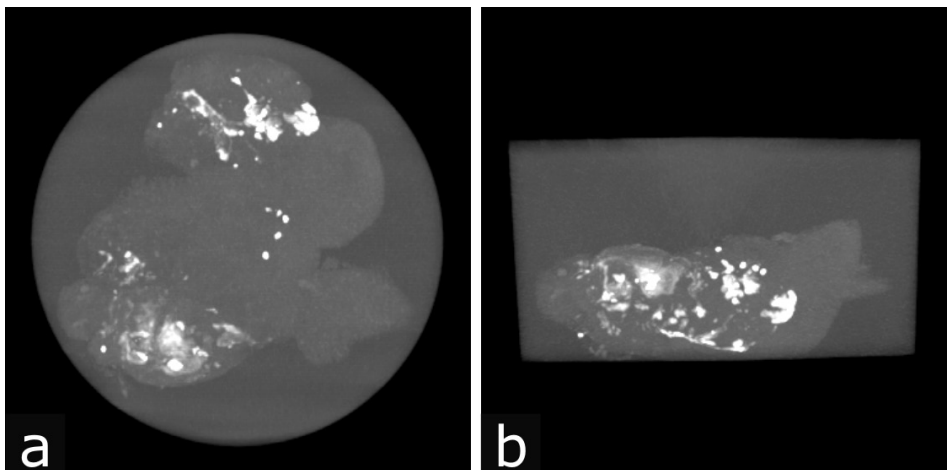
CT images (maximum-intensity projections) of the *ex-vivo* liver; top view (a) and side view (b). The radiopaque structures correspond with the HoAcAcMS depots
